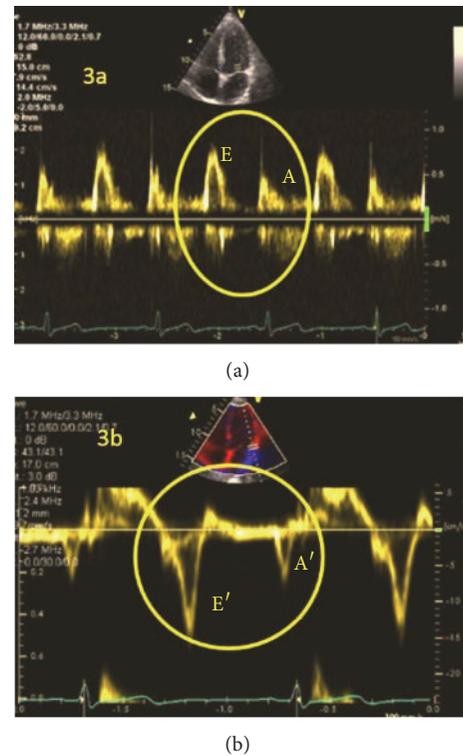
Normal diastolic function in PW-Doppler (a) or TDI (b) on the lateral side of the mitral annulus.
